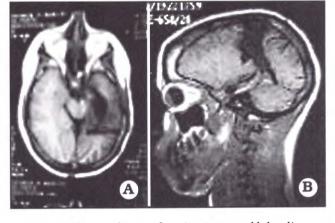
A. MRI: axial view showing temporal lobe disconnection, without resection. B. MRI: sagittal view showing central area resection with temporal lobe disconnection.
